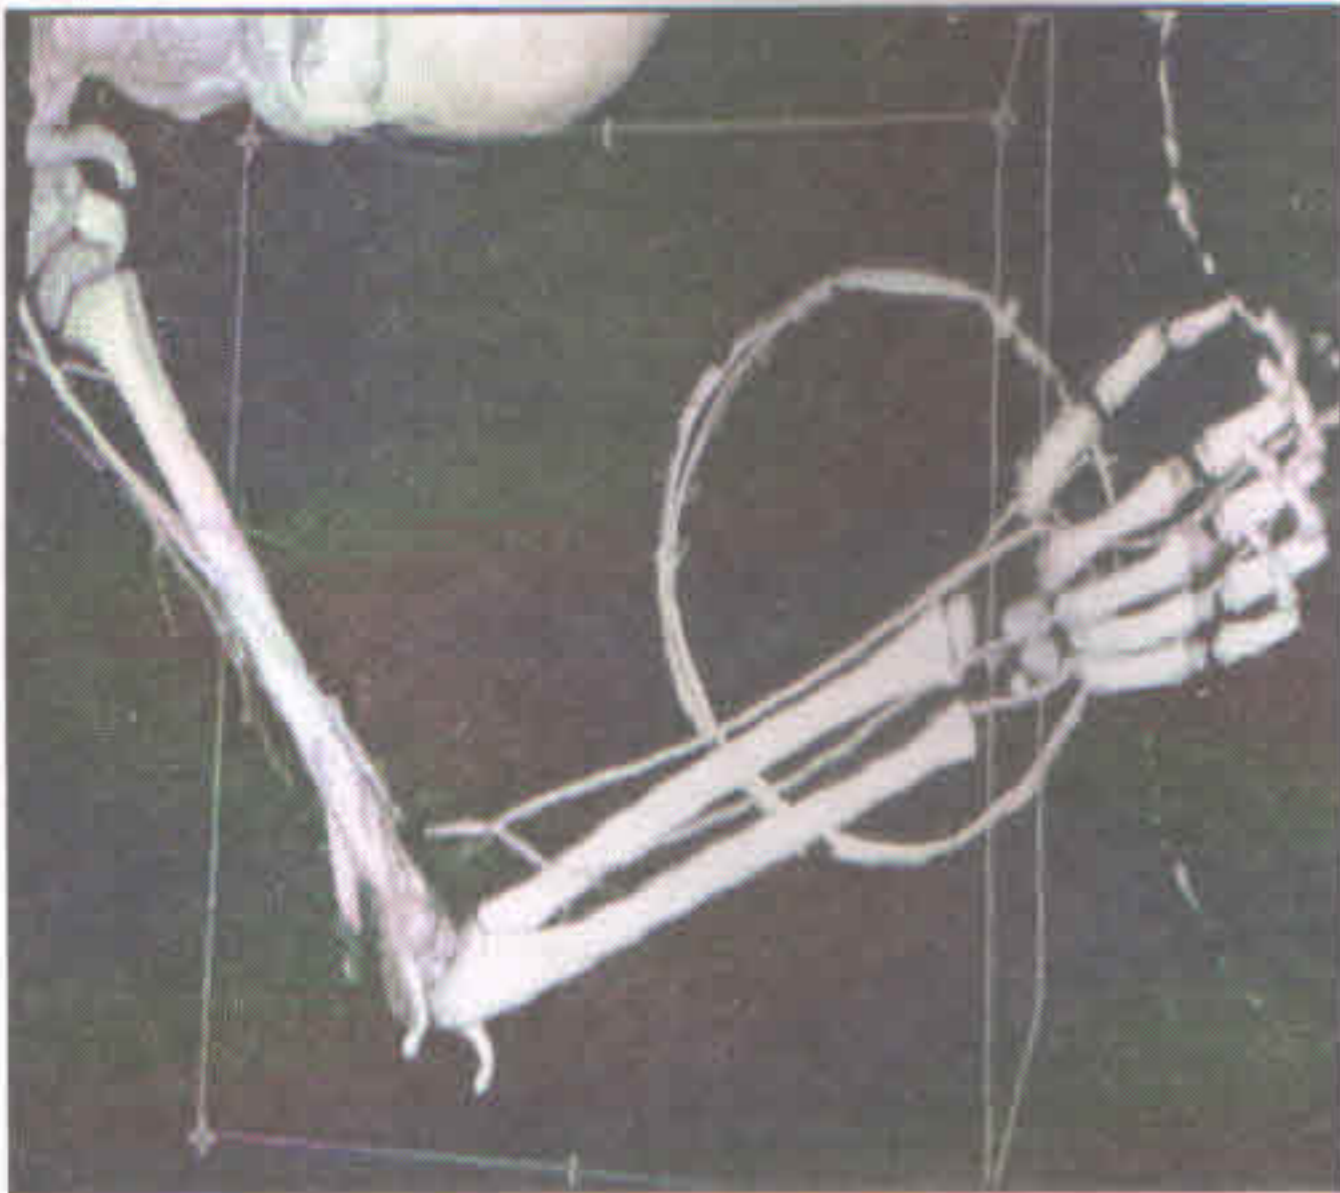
CT angiography showing vascular cut-off with collateral circulation
